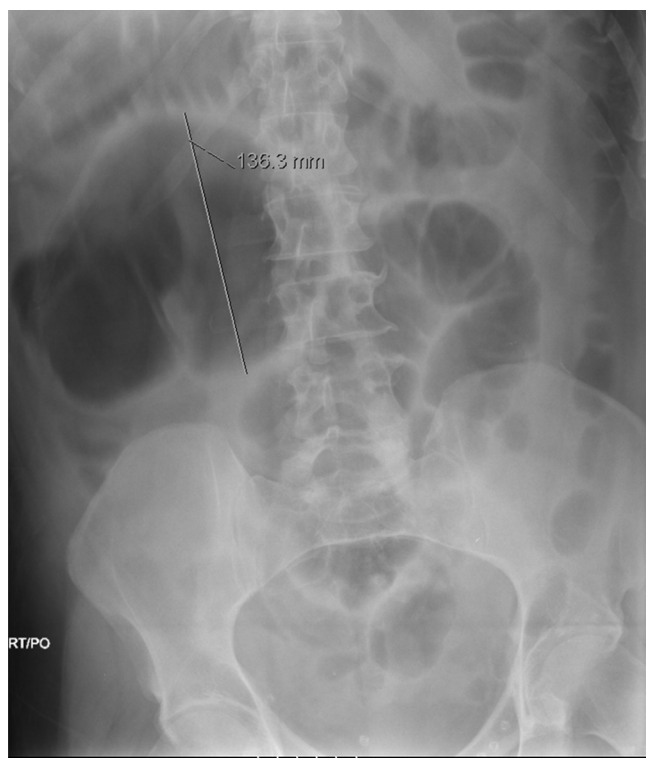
Abdominal radiograph showing a distended cecum.
